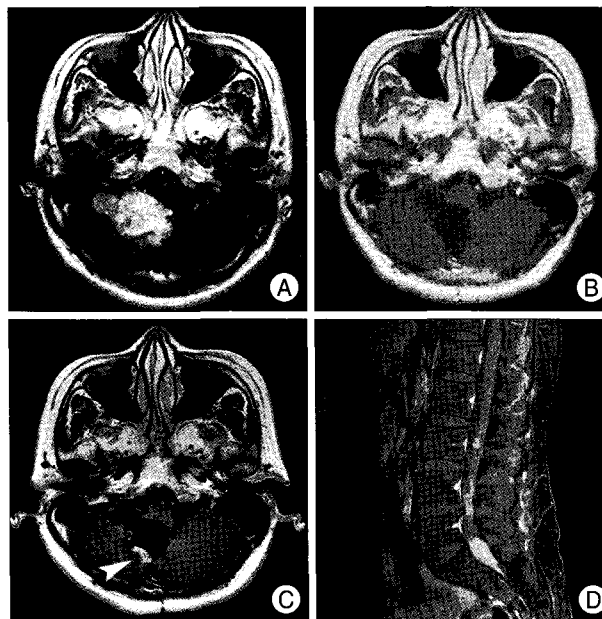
Preoperative T1-weighted contrast-enhanced magnetic resonance imaging (MRI) of the posterior fossa showing a fourth ventricle mass (A) and postoperative MRI showing total removal of tumor (B). MRI taken 6 years after operation showing a recurrent tumor (C) and spinal drop metastasis at the level of the L3-S1 vertebra (D).
